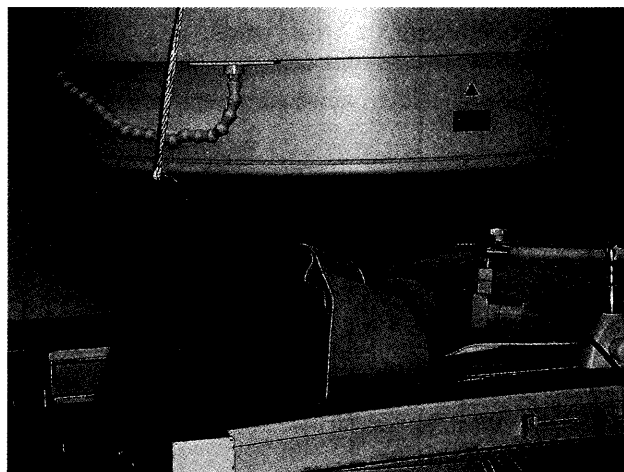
Appearance of a 0.2-T open-type MR imager. A subject elevates his arm in 30° increments using a dedicated device with 150° external abduction in the supine position.
